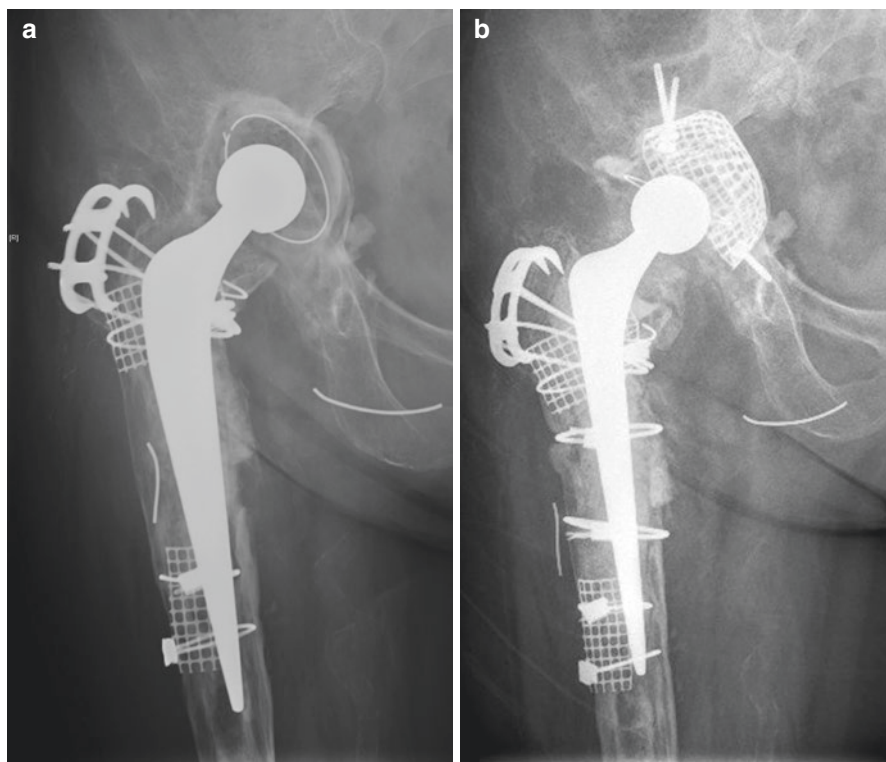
(a) Preoperative radiograph of the hip shows a failed impacting bone grafting used in cup revision surgery. (b) The hip was re-revised using a new impacting bone grafting with metallic mesh with a good clinical result
